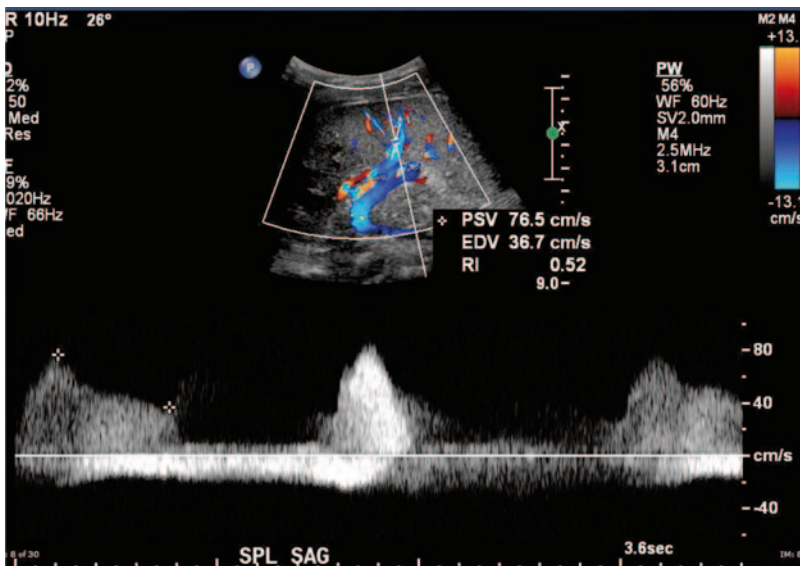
Doppler imaging of the same patient as in Fig. 8.9 shows the relationship of the laceration (*dark line*) to the left of the vessels. Free fluid is also seen at the hilum, and below the diaphragm (*lentiform dark line in the lower left corner of the scan*)
